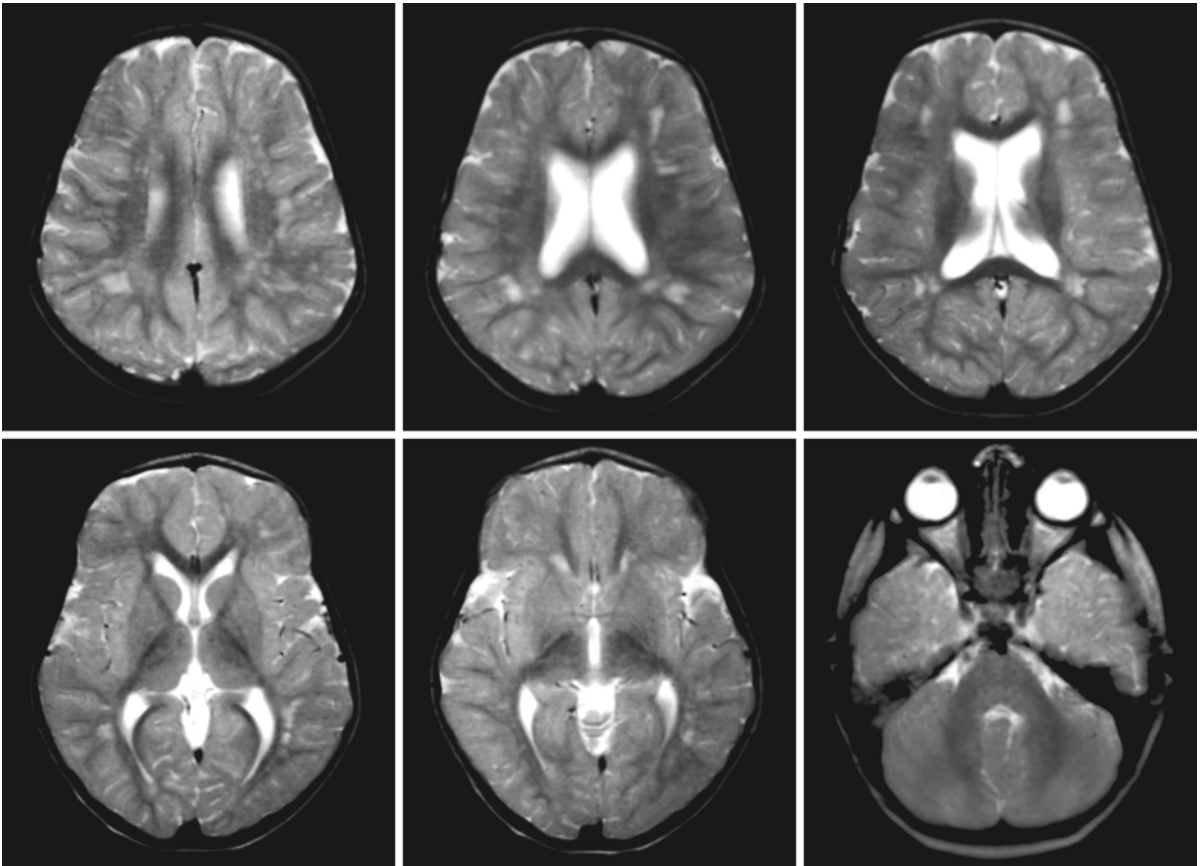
The transverse T_2 -weighted MRI series of this 3-year-old boy shows widespread patches of hypomyelination. Myelination is delayed for the age of the child, most evidently
